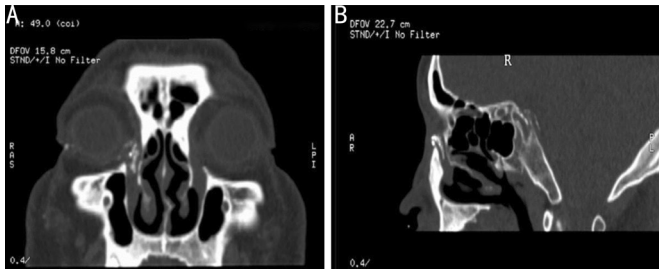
Three-plane reconstruction of CT-DCG-TPR-BTNC A: Coronal position; B: Sagittal position. Contrast agents were irregularly retained in the right lacrimal fossa and nasolacrimal duct. The contrast agent is Ioversol. CT-DCG-TPR-BTNC: Computed tomography dacryocystography based on the trend of nasolacrimal canal.
